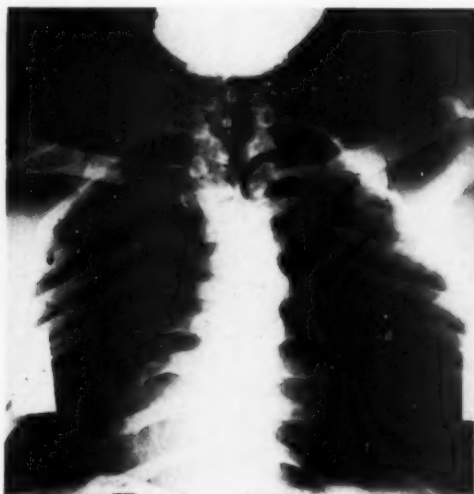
Roentgenogram showing malformation of lower cervical and upper dorsal vertebrae and ribs.
